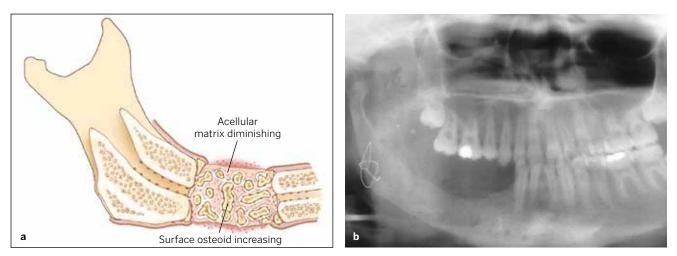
(a) By fusing graft particles together and to the host bone, the graft has produced sufficient osteoid to consolidate by 6 weeks. (b) Corresponding radiograph shows condensation of the cloudy graft appearance, indicative of osteoid production and graft organization. The radiolucent line between the graft and host bone has nearly disappeared as a result of osteoconduction between the graft and host bone edge. (Reprinted with permission from Marx and Garg.¹)
